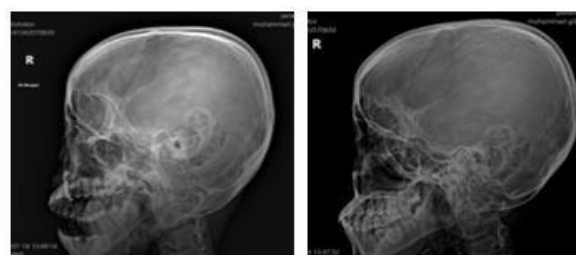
Radiograph of the Temporomandibular Joint, Axiolateral Projection, 250 Caudal Angle
